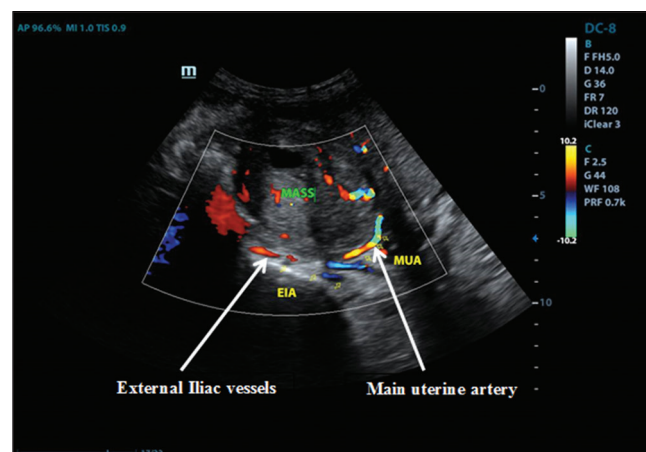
Color Doppler image of the uterine artery and the external iliac vessels in a patient with Stage IIIB cervical cancer
